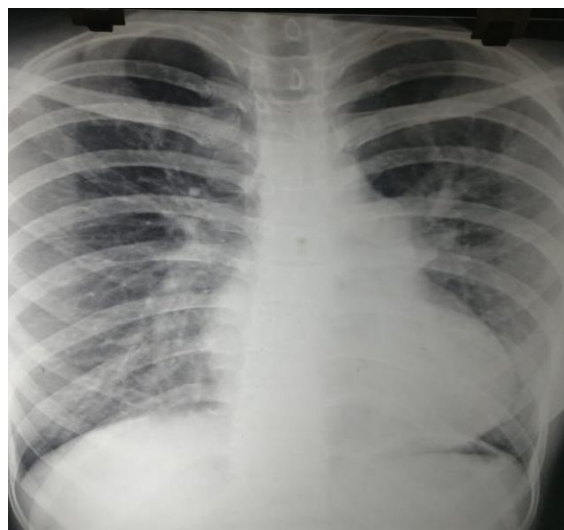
Pre-Operative X-ray Chest.
